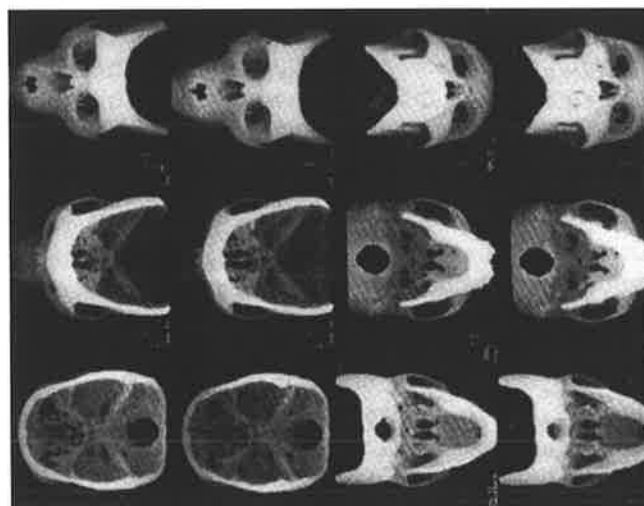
Stereo images of a 3D CT reconstruction of a dried skull used for determination of osseous landmarks for rotations about the x-axis of [27°, 36°], [72°, 81°], [117°, 126°], [225°, 234°], [270°, 279°] and [315°, 324°] in order down the left pair of columns and up the right pair.
